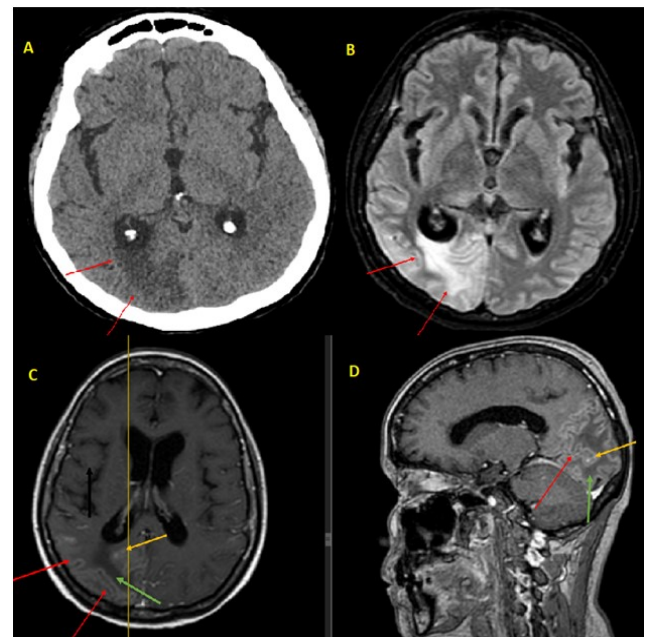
A. Computed tomography in the axial plane shows an ill-defined hypodense area in right occipital lobe (red arrows). B. FLAIR sequence in axial plane. Demonstrates area of hyperintensity involving cortical and subcortical white matter in the occipital lobe. That area also showed restricted diffusion with corresponding ADC hypointensity (not shown), compatible with acute infarcts. C and D. T1 sequences post contrast in axial e sagittal planes. There is parenchymal gyriform enhancement, indicating associated meningoencephalitis as well as evolving ischemic changes (red arrows). Leptomeningeal enhancement is observed (yellow arrows). There is also subcortical area of hypointensity in occipital right lobe representing vasogenic edema (green arrow)
